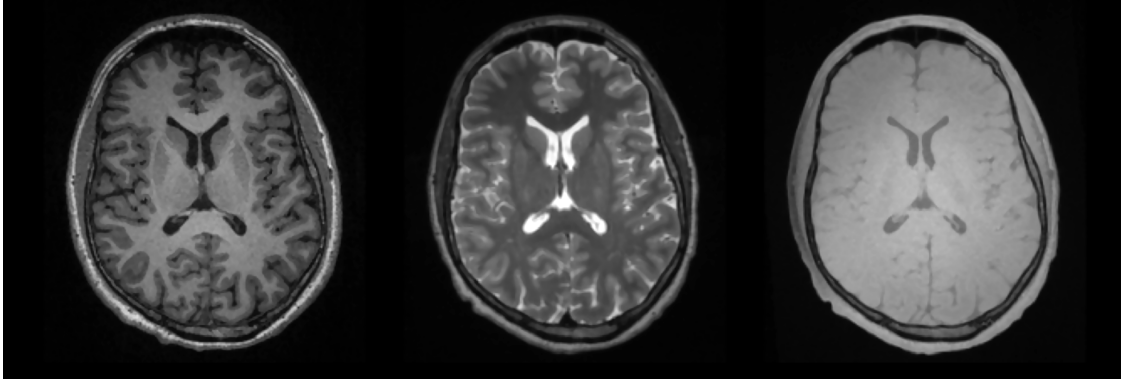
Axial slice acquired with T1, T2 and PD weighted MR imaging.
